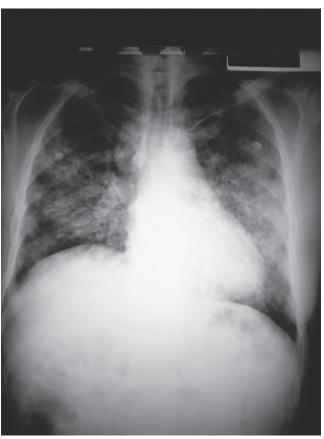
Posteroanterior Chest Radiograph Reveals Patchy Interstitial Infiltrates. Viruses and *Mycoplasma* are the most likely causes in an otherwise healthy patient, but many bacterial organisms may also produce this pattern.
